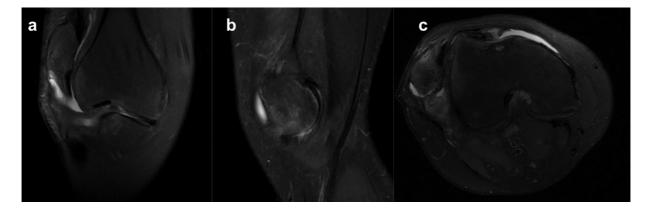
Magnetic Resonance Imaging (a) Coronal view. (b) Sagittal view. (c) Axial view.
